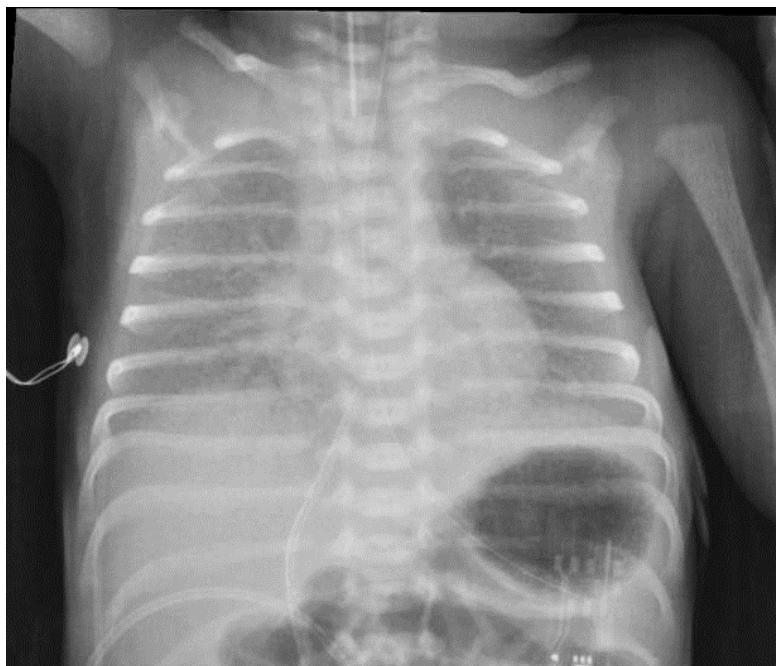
chest radiography showing a typical picture of RDS
